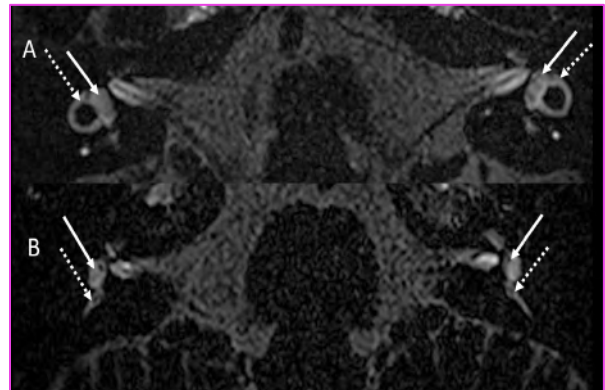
Patient (female, 53 years old) with a bilateral canal and utricular deficit associated with a bilateral vestibular atelectasis on the MRI A/ Axial 3D-FLAIR at the level of the upper part of the vestibule where the entire lateral canal semi-circular canal is displayed. Bilateral utricle (white arrow) and lateral ampulla (white dotted arrow) are collapsed. B/ Axial 3D-FLAIR at the level of the lower part of the vestibule demonstrating a bilateral normal saccule (white arrow) while the left and right posterior ampulla (white dotted arrow) are almost collapsed.
